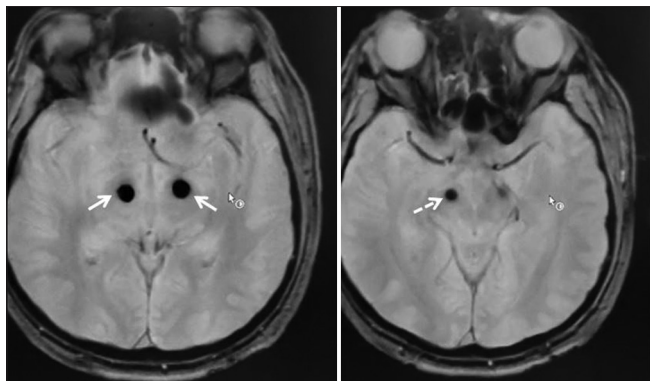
The cranial magnetic resonance imaging (MRI) sequences showing the bilateral electrodes of the STN-DBS. The electrode on the right side is located more inferior (jagged arrow)
